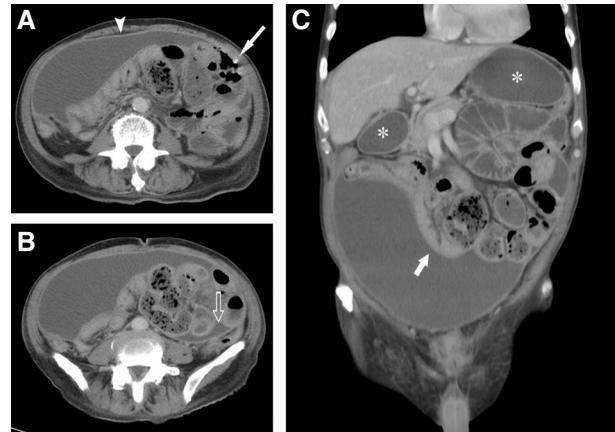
Abdominal computed tomography of tuberculous peritonitis. (A) Axial view demonstrated loculated ascites with a conspicuous thickened, contrast-enhanced membrane (arrowhead), and focal peritoneal calcification (arrow). Small-bowel loops were encased by the thickened membrane. (B) Loculated fluid collection (open arrow) within the tethered bowel loops and small bowel obstruction were also noted. (C) Coronal view revealed loculated ascites (asterisks) and encapsulated adherent small bowels at the left upper quadrant of abdomen with the characteristic cocoon-like picture (arrow).
